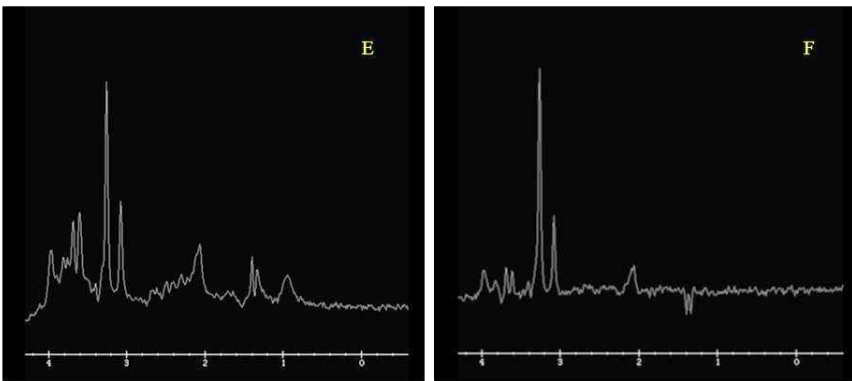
MRI of a 47-year-old man admitted after a focal prolonged seizure, showing a right-sided frontal glioma. A: Coronal T1 FLAIR; B: Axial FLAIR; C: T2; D: Contrast-enhanced T1 showing a small focus suspected to be of higher grade.
